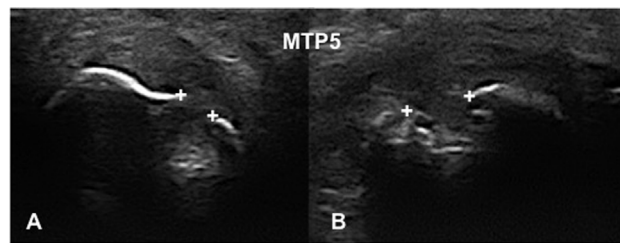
Ultrasound erosion of MTP5th. Erosion of the fifth MTP: discontinuity of bone surface (white cross) seen in transversal (A) and longitudinal view (B).
